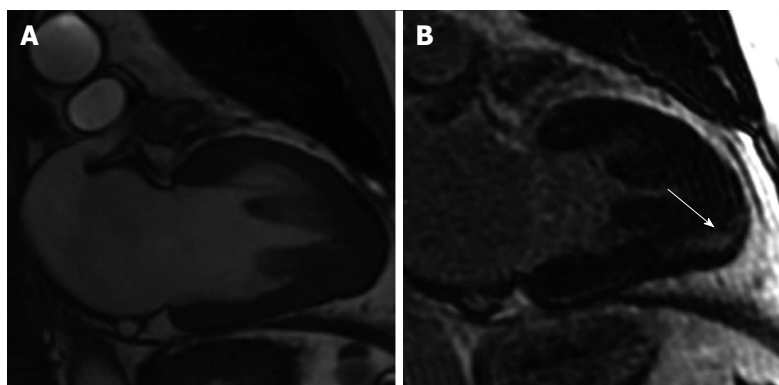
Cardiovascular magnetic resonance imaging. Long axis view (A) of the left ventricle showing apical regional hypertrophy; long axis view 10 min after Gadolinium injection; B: An abnormal hyper-enhancement of the apical segment is visible (white arrow).
